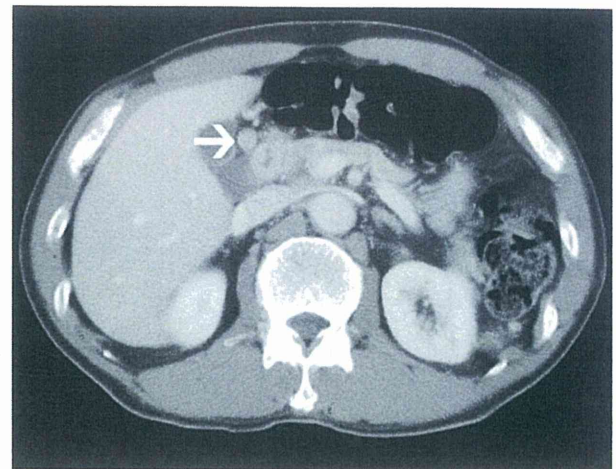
CT in December 2007 detected an enlarged suprapyloric lymph node measuring 12 × 9 mm in size
